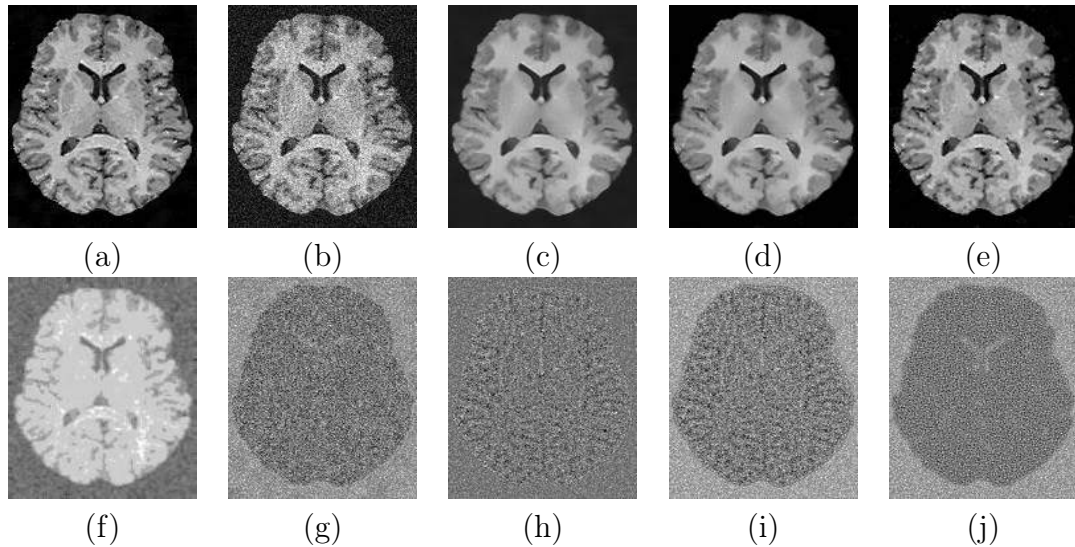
Synthetic image data T1-weighted MR image: (a) Noise-free image, (b) noisy image (noise level = 9%), (c) NLM-output [46], (d) UNLM-output [42], (e) PCNNNI_IUNLM output, (f) Time Matrix, (g) actual noise, (h) residual of NLM, (i) residual of UNLM, (j) residual of PCNNNI_IUNLM.
